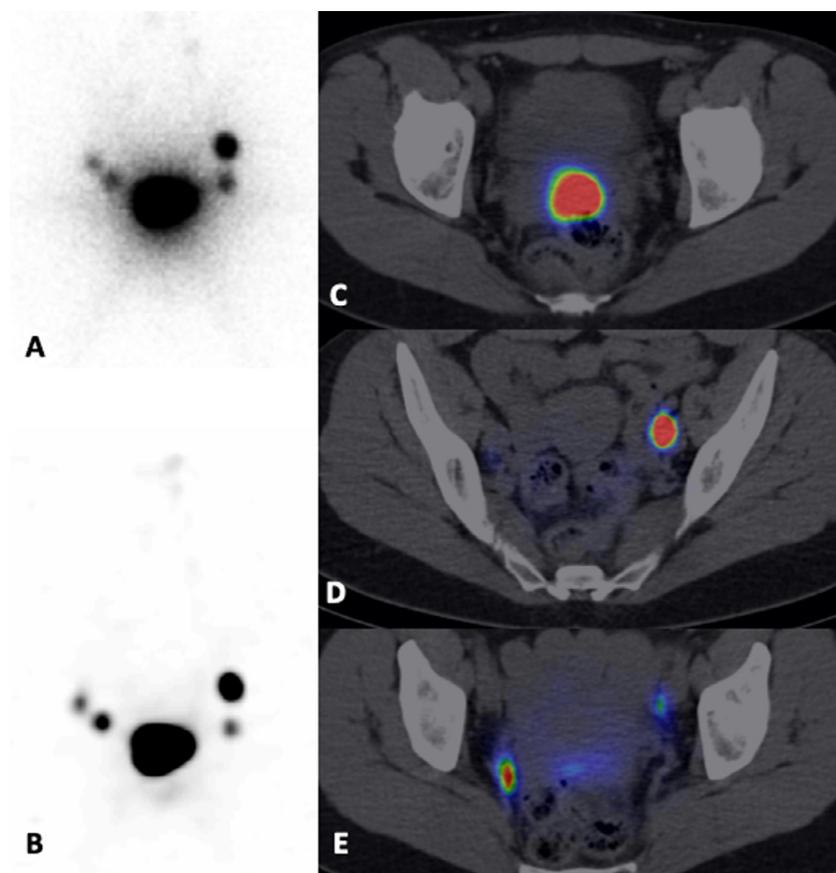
A 50-year-old woman with FIGO IB1 cervical adenocarcinoma underwent sentinel lymph node scintigraphy. After injection of about 120 MBq in four peritumoral points, planar images were acquired at 15 and 60 minutes (A and B). The fused SPECT/CT views showed the cervical injection site with no pelvis contamination (B), bilateral pelvic SNL drainage with a habitual iliac external left node uptake and a rarer right para-metrial node uptake (D and E).
